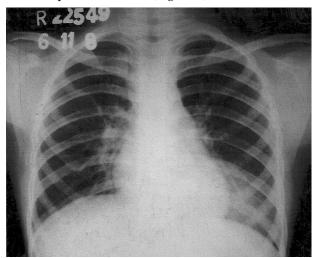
Chest radiograph (postero-anterior view) showing diffused haze in the lower zone in the left paracardiac region suggestive of left lower zone pneumonitis.
